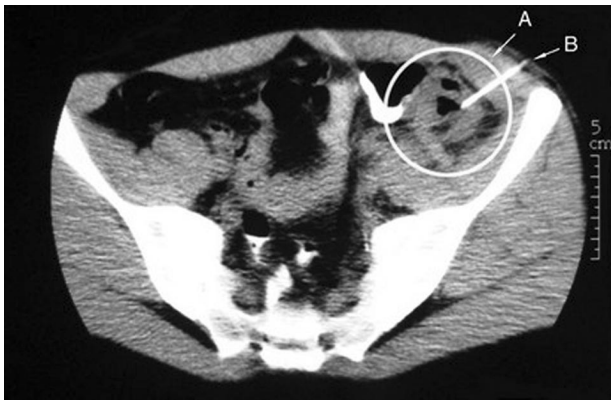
Treatment of psoas abscess by percutaneous drainage under computed tomography guidance. The abscess is circled in white (A). The percutaneous puncture point is identified by B.
